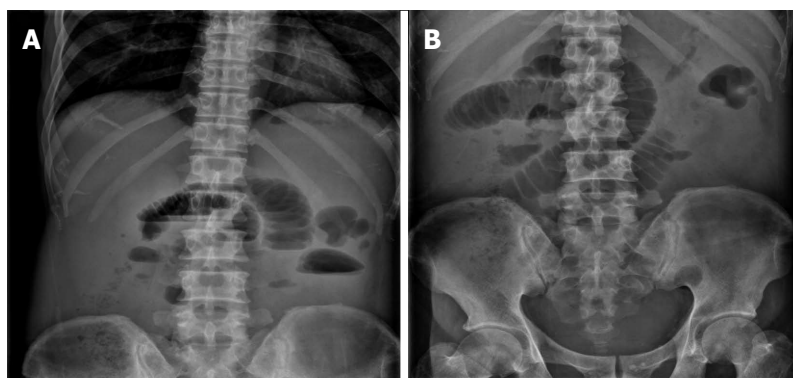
Plain abdominal radiography revealed incomplete small intestinal obstruction. A: The flat film of the abdomen in the standing position showed dilated small bowel loops with air-fluid levels; B: The flat film of the abdomen in the horizontal position showed dilated small bowel.
